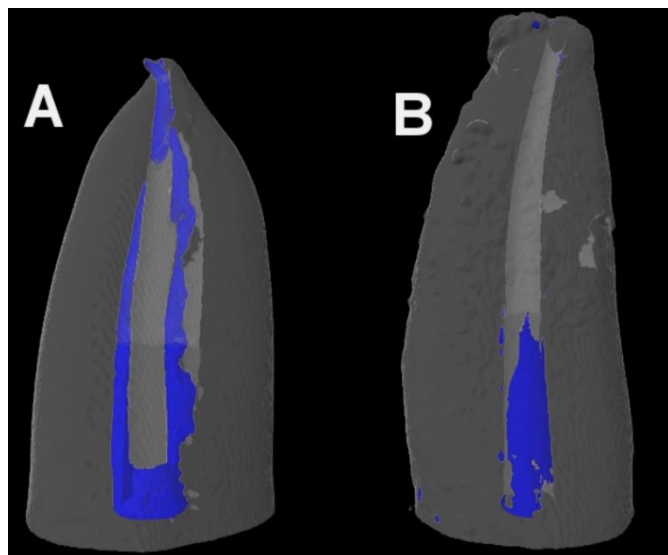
Examples of root canals with high; A) Reciproc; B) lowProTaper + ProTaper Next volumes with residual amount of filling material after retreatment as visualized under micro CT
